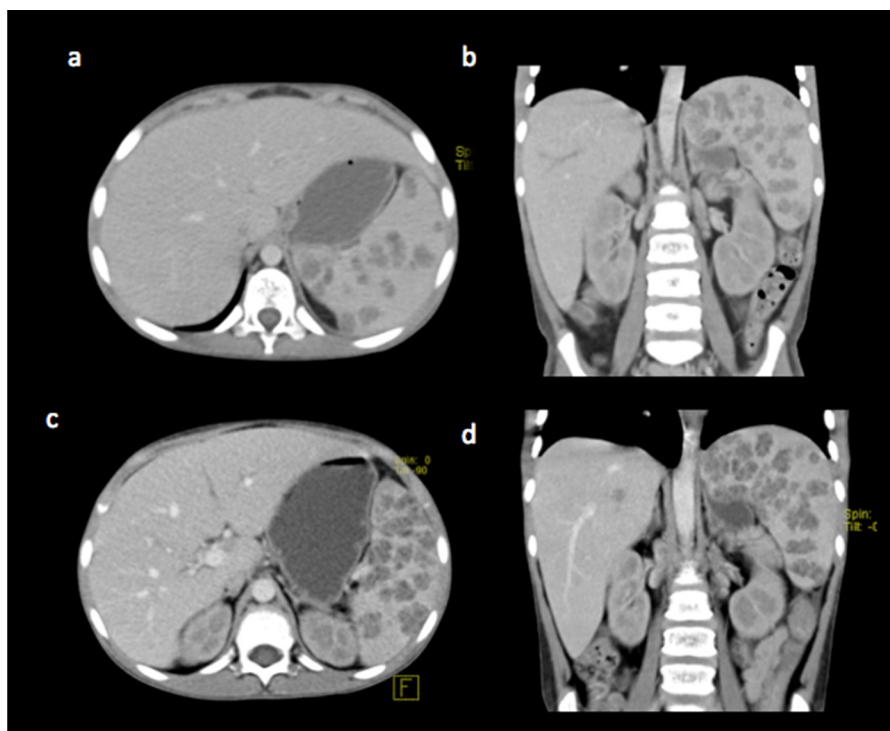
(a) Axial and (b) coronal contrast-enhanced computed tomography (CECT) abdominal sections showing hepatomegaly and multiple hypodense round lesions in the spleen that did not enhance after the administration of intravenous contrast agent. (c) Axial and (d) coronal CECT sections showing persistence of the hepatomegaly and progression of the spleen lesions.
